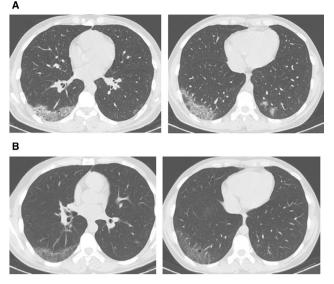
Transverse High Resolution CT scans of the chest of a patient with ulcerative colitis and COVID-19. (A) At the onset of symptoms of COVID-19, CT shows patchy ground-glass opacities affecting the subpleural lung parenchyma bilaterally, indicating interstitial pneumonia. (B) After 10 days (7 days after Infliximab therapy), CT shows a reduced extent and density of the ground-glass opacities.
